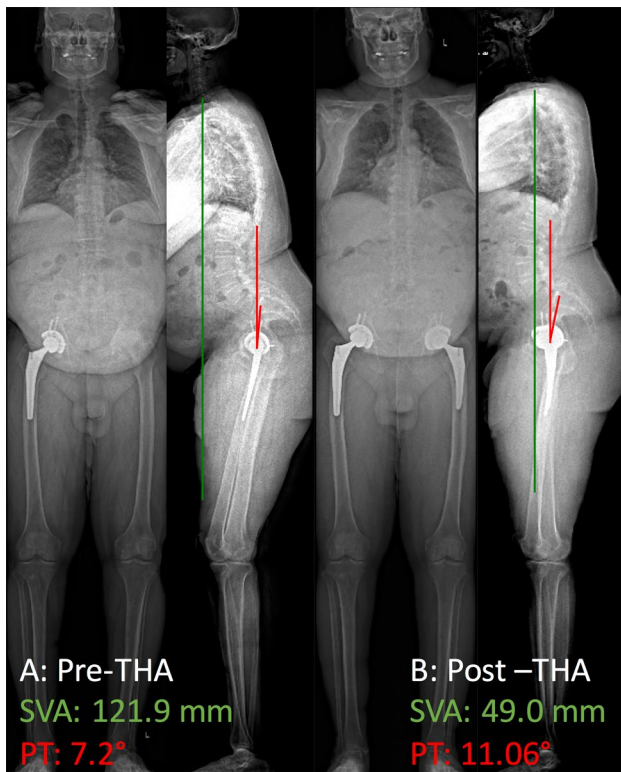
AP and lateral radiographs of the same patient pre-(left) and post-(right) total hip replacement (THA). Note the increase in pelvic tilt THA with reduction in SVA and correction of positive sagittal malalignment
